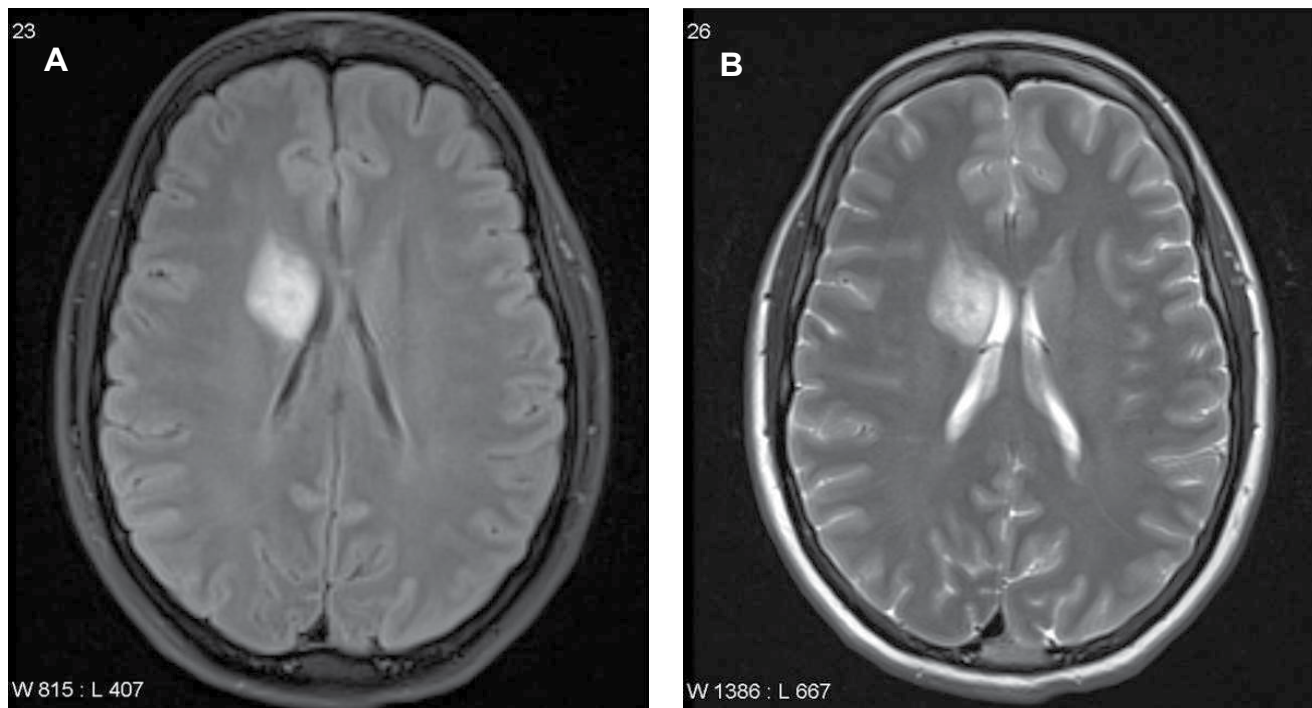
Initial radiologic findings. Brain MRI demonstrates 3.2 × 2.8 cm lesion without contrast enhancement in the T1 weighted image. (A) and with edema on flair image; (B) before biopsy and radiation therapy. MRI: magnetic resonance imaging.
